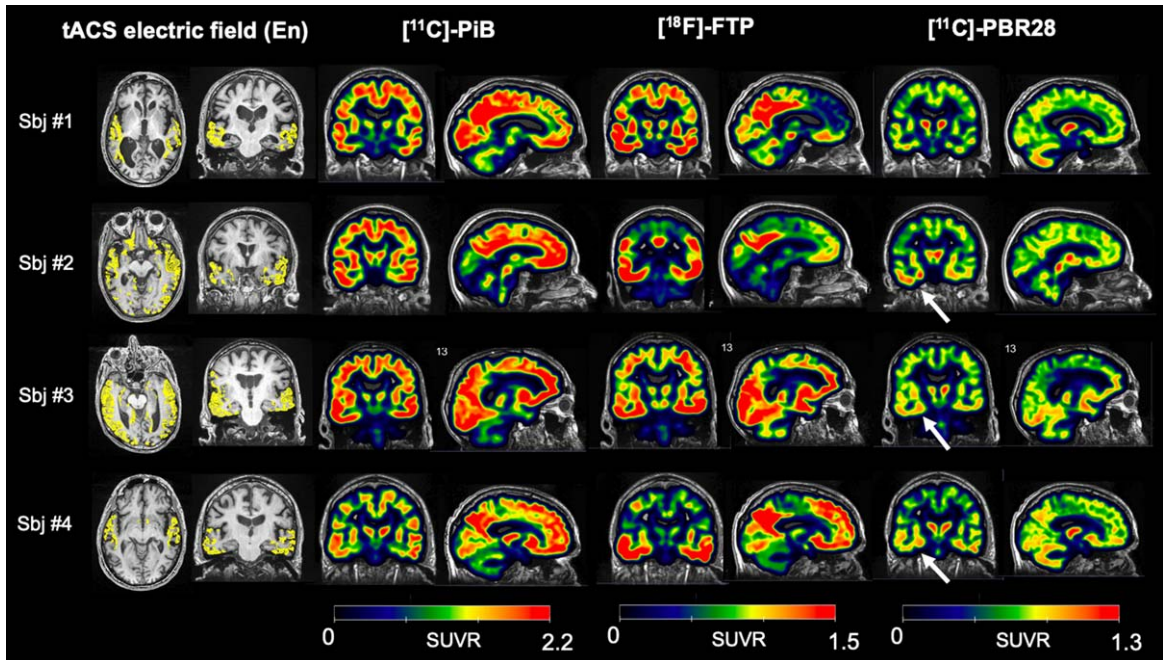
tACS targets and SUVR parametric images for all participants. Axial and coronal views of the normal electric field induced by tACS in each participant are reported (yellow,  $E_n > 0.25$  V/m on the structural MRI for anatomical reference), showing the tACS field affecting primarily the bilateral temporal lobes (left). Individual sagittal and coronal views of SUVR maps of  $[^{11}\text{C}]\text{-PiB}$ ,  $[^{18}\text{F}]\text{-FTP}$  and  $[^{11}\text{C}]\text{-PBR28}$  data collected at baseline for each patient are shown, displaying high levels of amyloid- $\beta$  in all the participants, as well as significant p-Tau accumulation and signs of neuroinflammation (white arrows) in the bilateral temporal lobes, thalamus and parietal regions. Note: images are shown in radiological convention.
